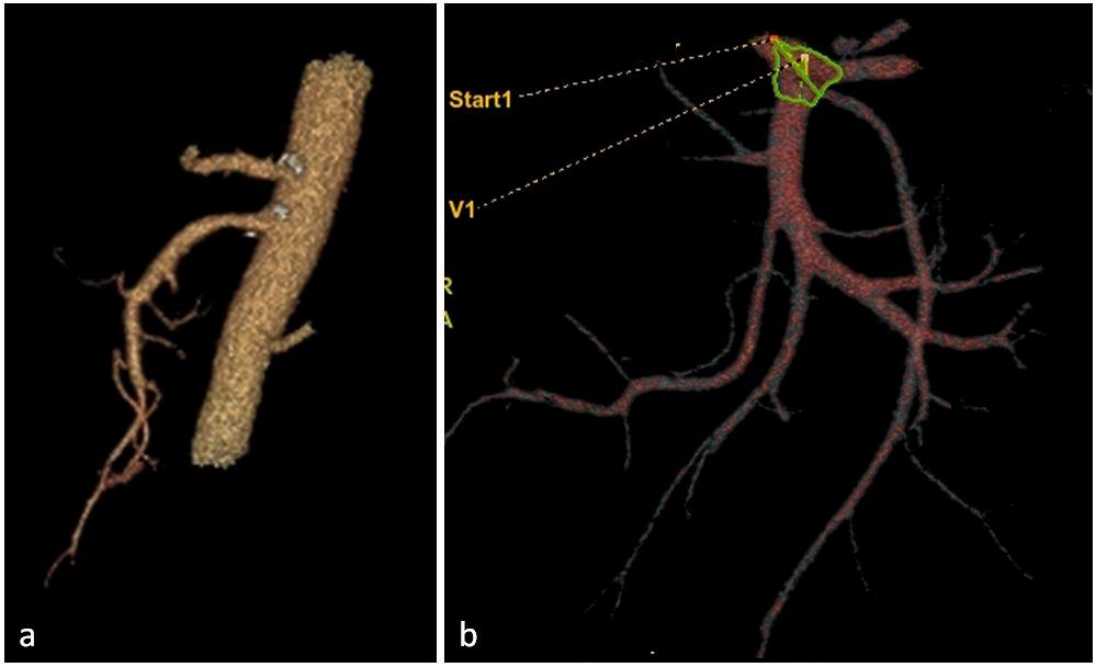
a) Three-dimensional volume-rendered CT angiogram shows the superior mesenteric artery and its branches; b) Three-dimensional volume-rendered CT angiogram shows the superior mesenteric vein and its branches.
